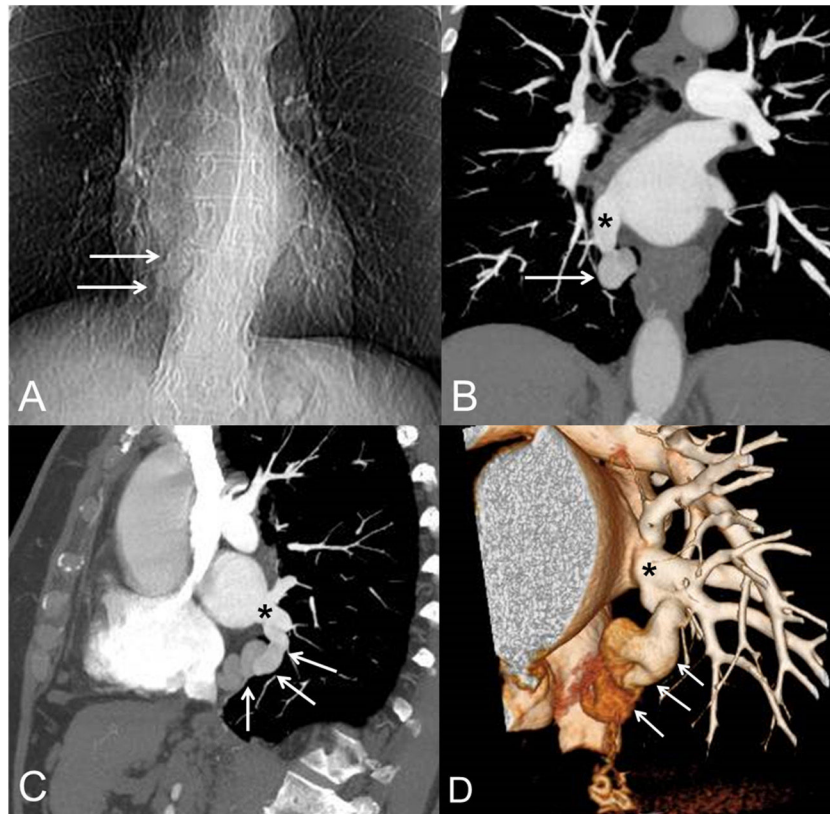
(A) Posteroanterior chest radiograph shows an abnormal contour of the right inferior mediastinum (arrows). (B) Coronal MIP (maximum intensity projection) CT image shows a dilated paraesophageal vein (arrow) draining into the right inferior pulmonary vein (asterisk). (C) Sagittal MIP CT image shows the tortuous paraesophageal vein (arrows) draining into the right inferior pulmonary vein (asterisk). (D) Volume-rendering CT image (from a right posterior view) shows the tortuous and dilated collateral vein (arrows) draining into the right inferior pulmonary vein (asterisk).
